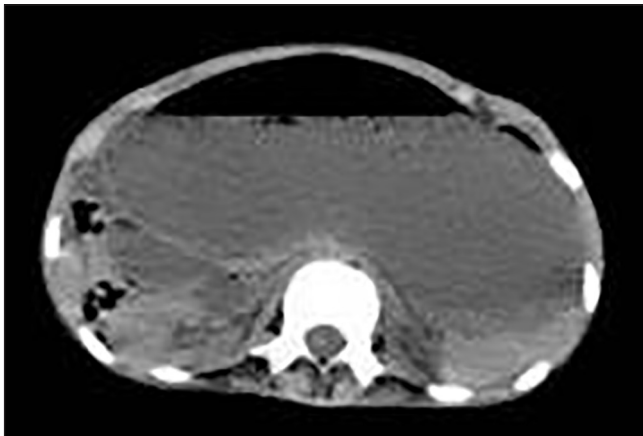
Preoperative abdominal computed tomography (CT) Abdominal CT confirm the presence of free intraperitoneal air and intrapelvic effusion
